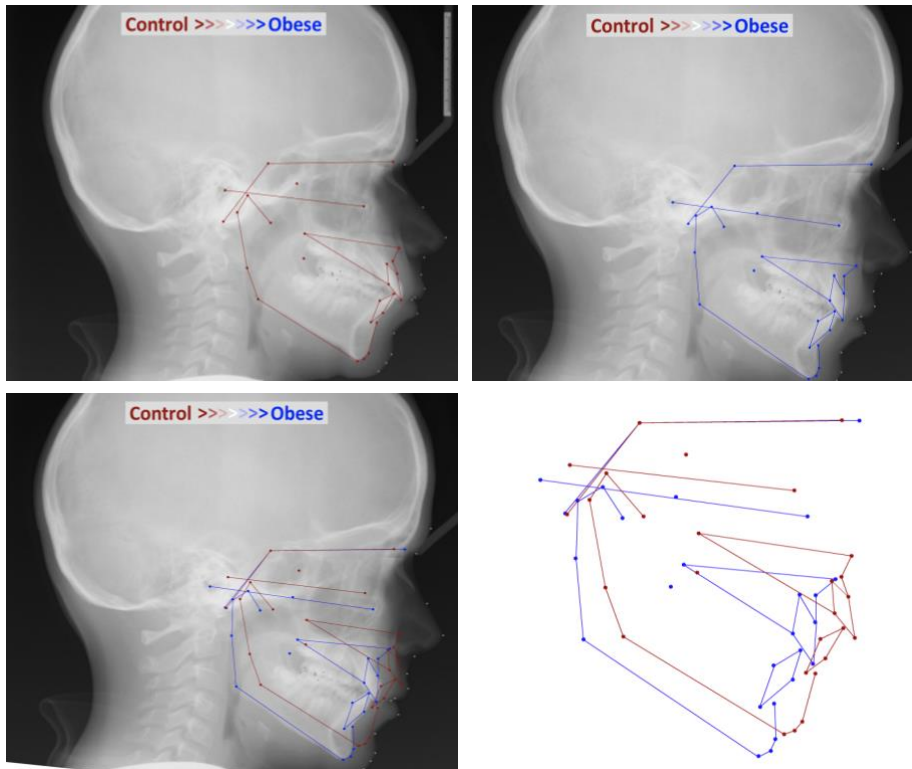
Interpolation of the LDA onto a cephalometric radiograph and wireframes showing the control (A, red) and obese (B, blue) ends of the distribution of patient in our dataset. (C and D) superimposition of the control and obese ends of the linear discriminate analysis using the cranial base (Sella-nasion-basion) for registration
